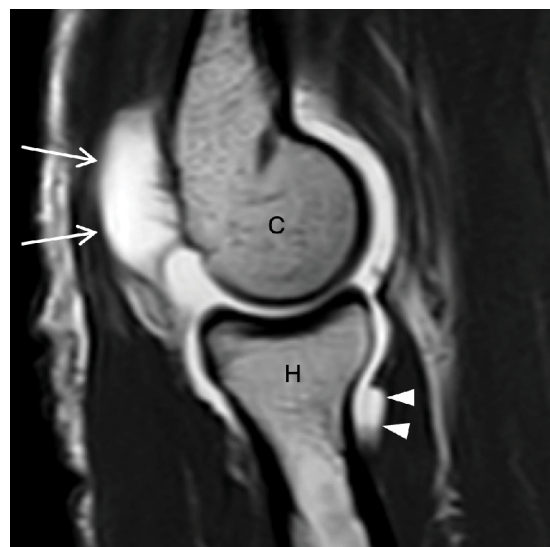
Sagittal T1-weighted image: huge posterior (arrows) and radial head (H, arrowheads) capsular recesses with minimal anterior dislocation of capitulum humeri (C) in a case of capsular laxity.
